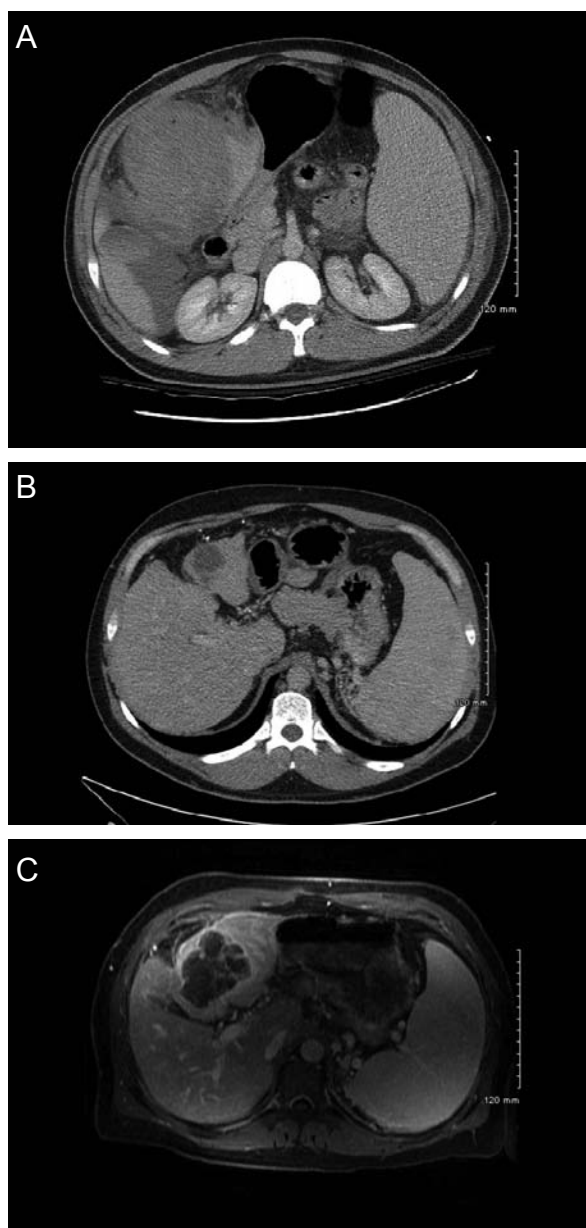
CT images showing regression rather than progression of the liver lesion, (A) initial presentation in 2003, (B) diminished to 3.0 cm in 2007, and (C) progression in 2008.
